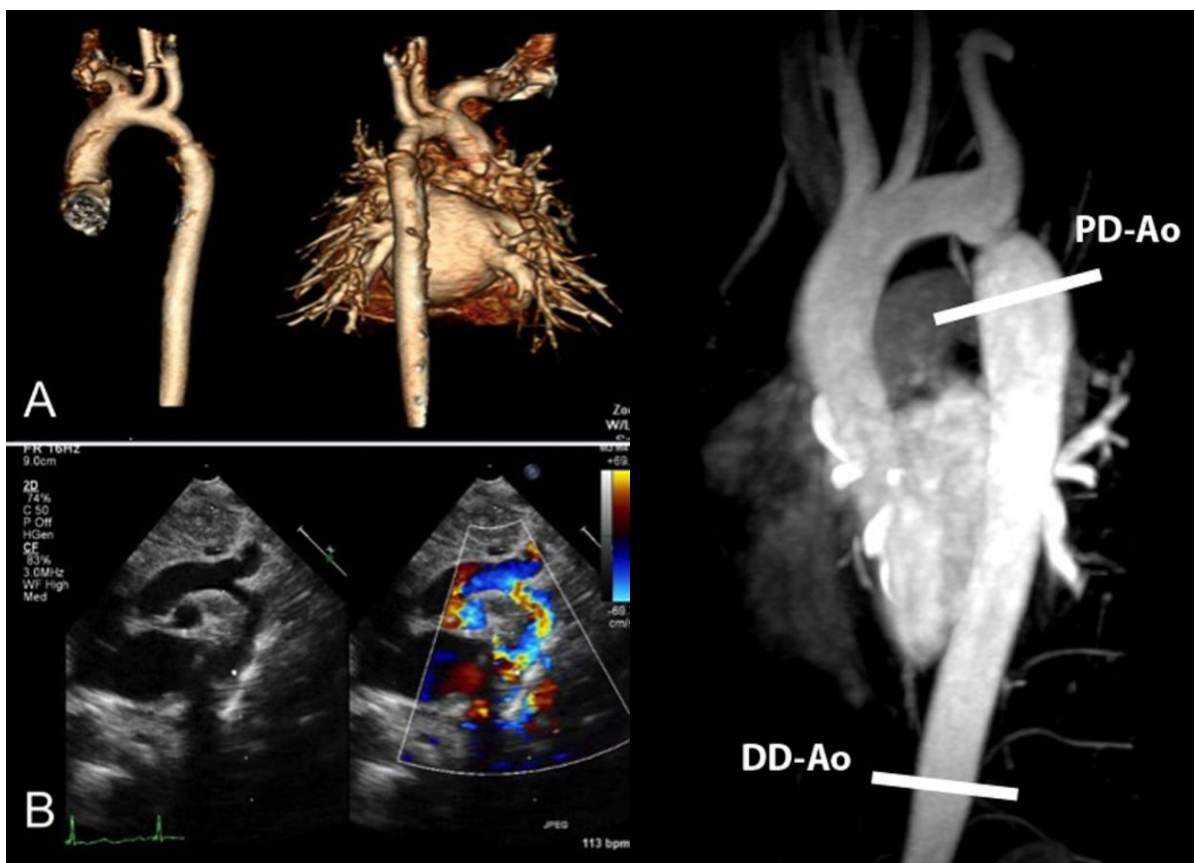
Coarctation imaging. (A) 3D CTA of a discrete distal coarctation. (B) 2D and coloured Doppler echocardiogram of a distal COA³⁶. (C) PC-MRI of the proximal descending aorta (PDAo) and the distal descending aorta (DDAo)³⁷.
